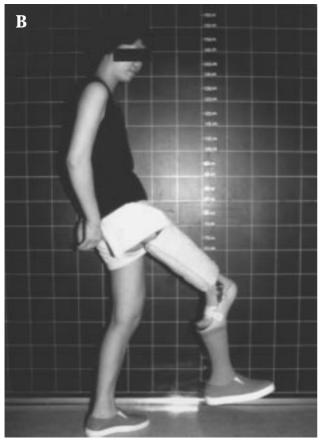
Case 2. (A) Pelvic roentgenogram showing osteosynthesis of the residual femur on the ilium with screws and the fibula on the medial aspect of the limb after rotation. (B) Photograph of the patient wearing the prosthesis 3 months after surgery.
